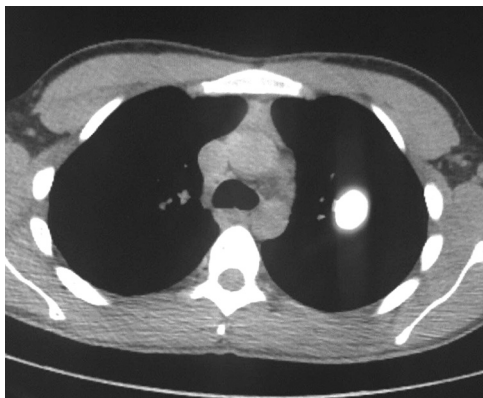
PET CT showing discrete high signal lesion within the pulmonary parenchyma.
